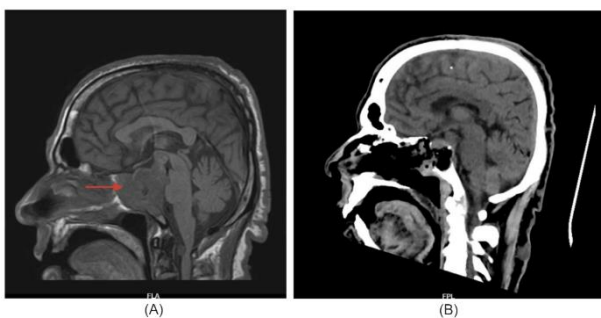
(A) Sagittal section of pre-operative MRI Brain showing hyperintense, minimally enhancing lesion in sellar and suprasellar regions (red arrow) compared with (B) Sagittal section of post-operative CT.
